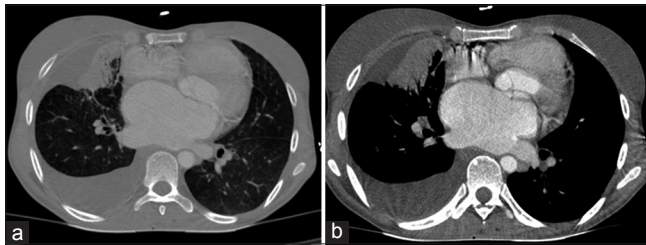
(a) Axial HRCT and (b) Corresponding mediastinal window showing consolidation in the right middle lobe with pleural effusion and in a case of pulmonary tuberculosis
